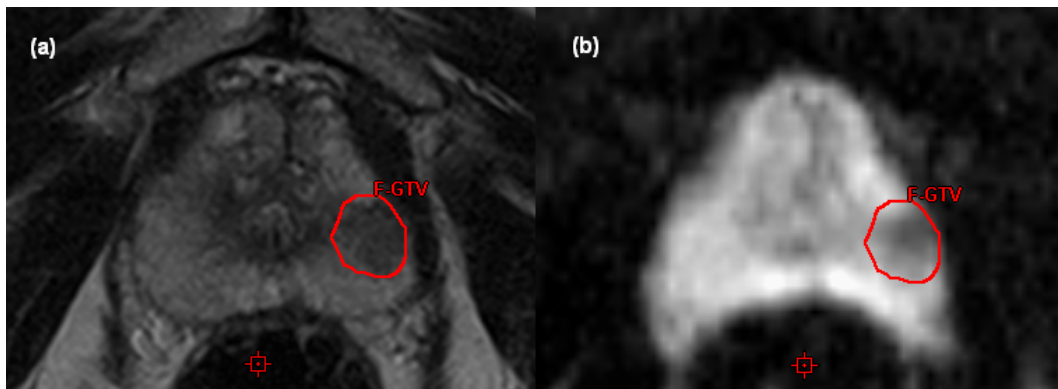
Example of F-GTV delineation on (a) T2 weighted and (b) DWI MRI
